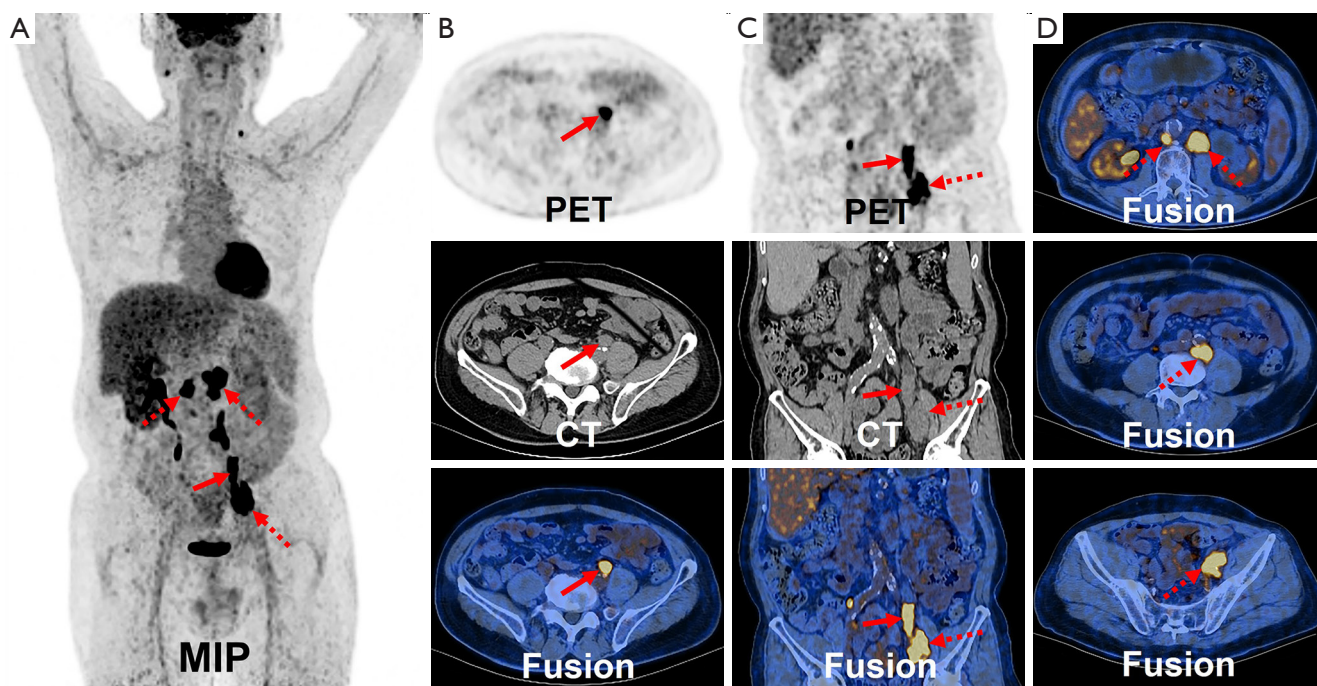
^{18}F -FDG PET/CT imaging of ureteral DSRCT. (A) The anteroposterior 3-dimensional MIP demonstrated increased metabolic activity in the middle ureter (long arrow), paraaortic lymph nodes, and left iliac vascular lymph nodes (dashed arrows). (B,C) Transverse images and coronal images showed lesions (long arrows) confined to the ureteral lumen with increased ^{18}F -FDG uptake, with SUVmax values of 10.5, and a heterogeneous increase in ^{18}F -FDG uptake in the left inguinal lymph node (dashed arrows), with SUVmax values of 11.3. (D) Transverse images showed a heterogeneous increase in ^{18}F -FDG uptake in the lymph nodes adjacent to the abdominal aorta (dashed arrows), with SUVmax values of 10.6. MIP, maximum intensity projection image; PET/CT, positron emission tomography-computed tomography; ^{18}F -FDG, ^{18}F -fluoro-2-deoxy-d-glucose; DSRCT, desmoplastic small round cell tumor; SUVmax, maximum standardized uptake value.
